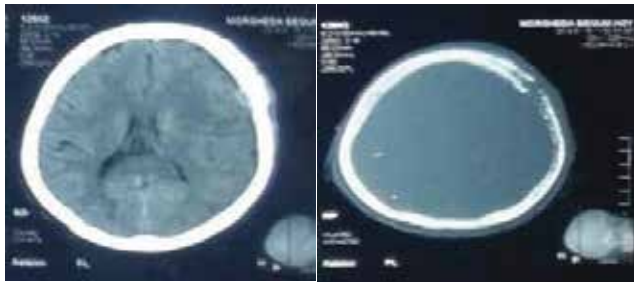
Non contrast CT head of the presented case showing a destructive, osteolytic mass lesion involving left fronto-parietal region.
